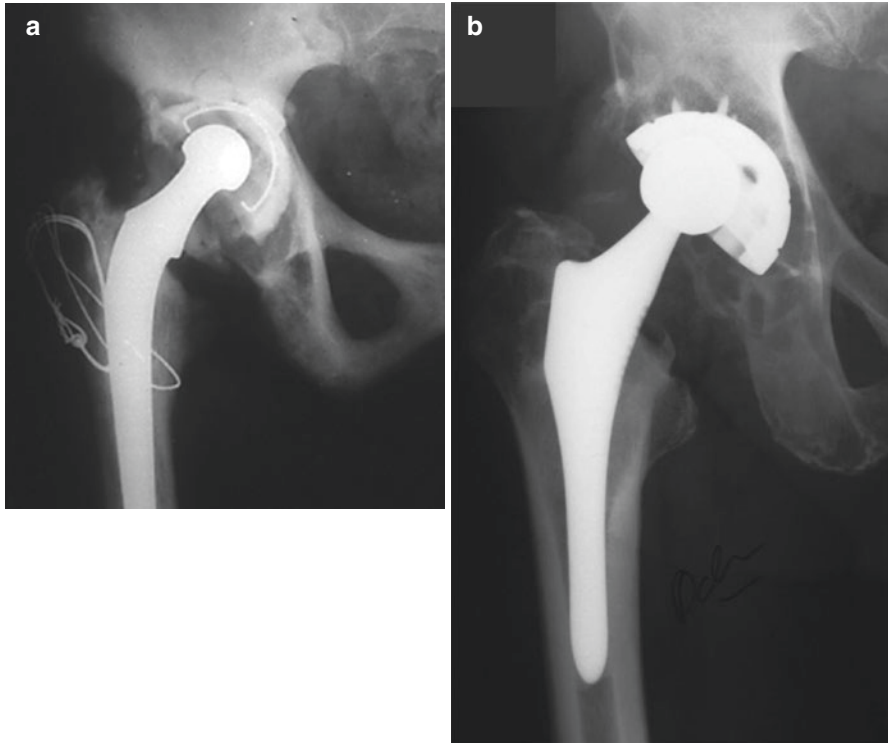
(a) Anteroposterior radiograph of the hip showing acetabular osteolysis around a cemented cup. Bone resorption occurs in a linear manner, resulting in degradation of the bone at the cement-bone interface and loosening of the implant over the time. (b) Anteroposterior radiograph of the hip showing acetabular osteolysis around a cementless cup. The areas that develop ingrowth become osseointegrated and are resistant to fluid and particles migrating along the interface. Extensive bone loss can occur without affecting implant stability
